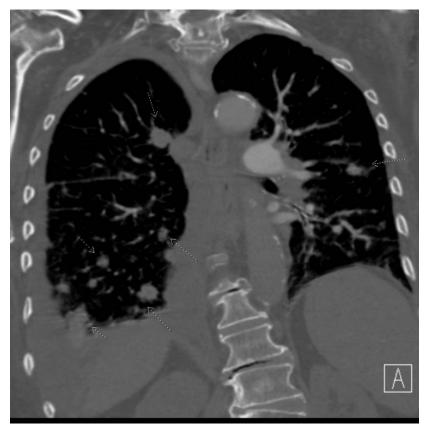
March 2023. CTA chest with contrast. Coronal view. Revealed worsening metastases including increased size and number of pulmonary metastases with involvement of the pleura.
